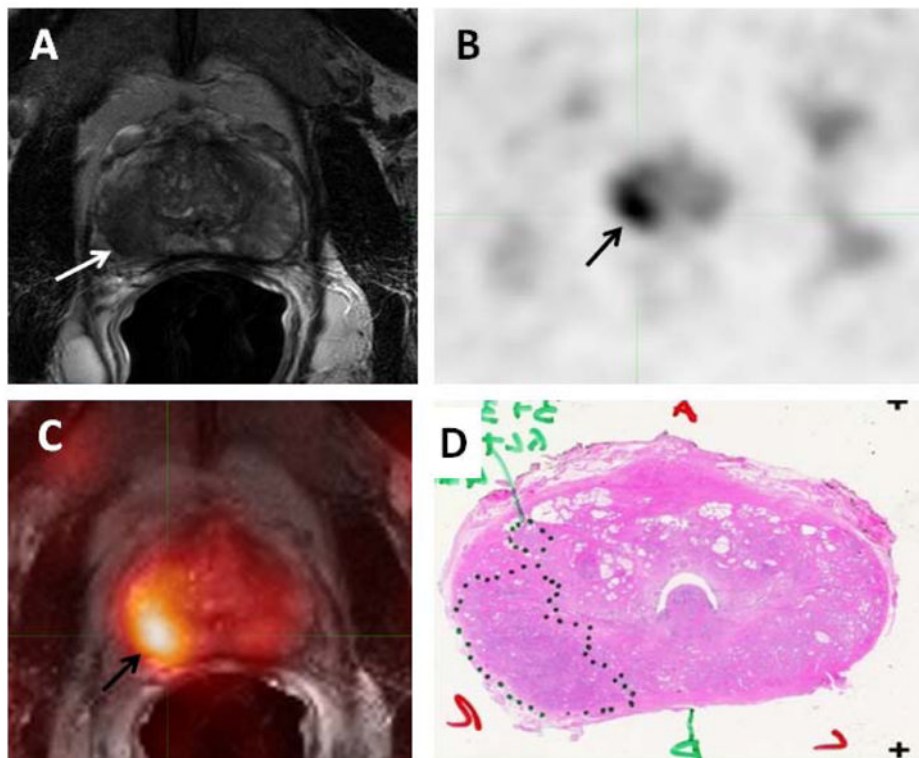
58-year-old male with prostate cancer. Axial T2-weighted MRI (A) demonstrates a low signal intensity focus in the right mid gland peripheral zone (white arrow), which shows ^{11}C -Acetate uptake in the axial PET image (black arrow) (B). Fused ^{11}C -Acetate PET/MRI (C) better localizes the tumor (black arrow). Corresponding pathology shows a Gleason 3+4 tumor in the right mid-peripheral zone (inked in black) (D).
